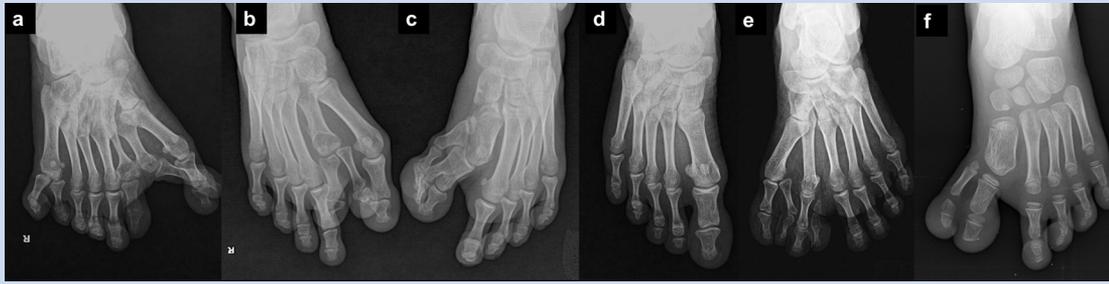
Foot radiographs of several affected individuals: (a) metatarsal type of preaxial polydactyly and cutaneous syndactyly with phalangeal type postaxial polydactyly (Individual IV:2), (b) mesoaxial polydactyly and cutaneous syndactyly (Individual IV:3), (c) all the phalanges of the first toe are triplicated with short first metatarsal (Individual IV:4), (d) broad hallux (Individual III:14), (e) duplicated T1 and T2 with eight toes (Individual III:12) and (f) duplicated hallux with broad first metatarsal (Individual III:18).
